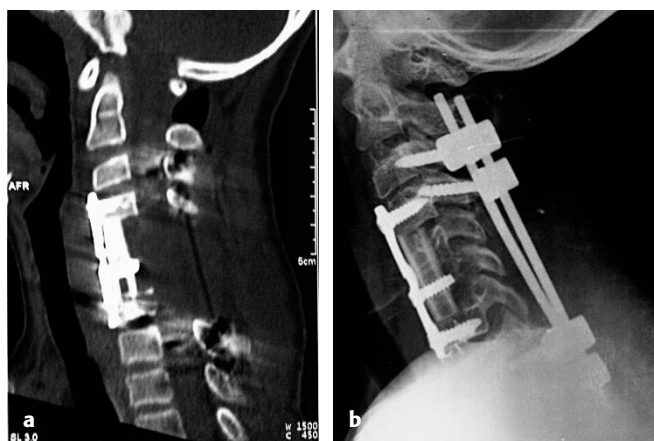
Postoperative x-ray showing complete tumor excision, fibulae strut graft in situ and circumferential fixation with plate and screws used anteriorly, and lateral mass and pedicle screws used posteriorly.
